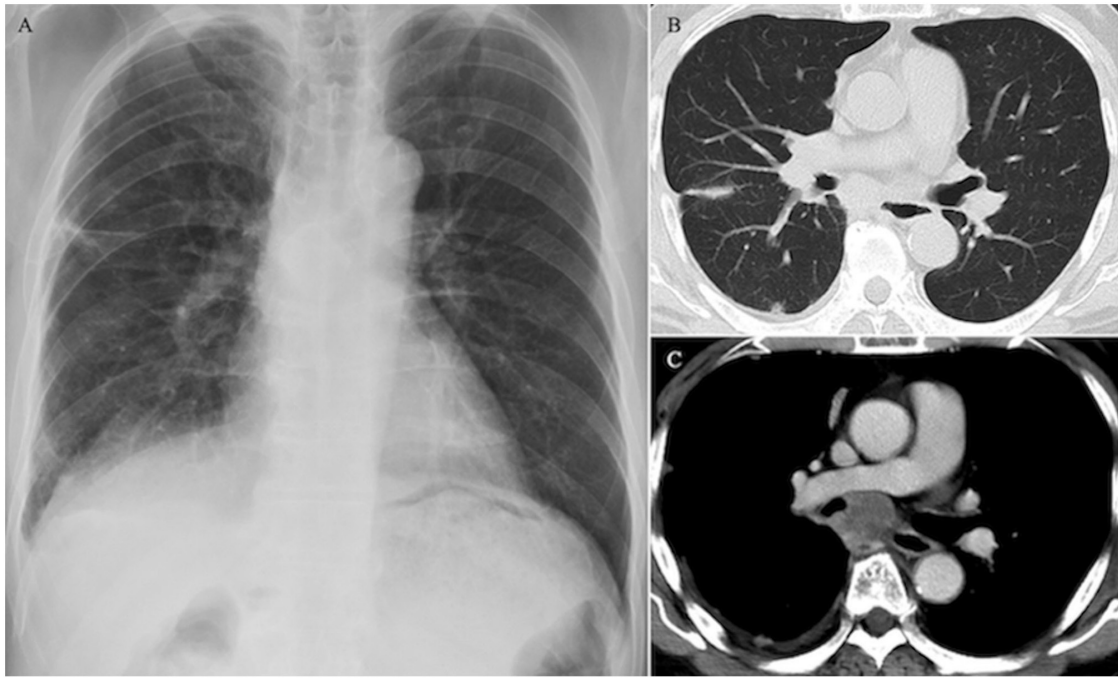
Radiography and CT findings. (A) Chest radiography revealed linear opacity in the right middle lung field. (B) Trunk CT revealed multiple thickenings in the right pleura and right pleural effusion. (C) Trunk contrast-enhanced CT revealed a hilar mass shadow with contrast enhancement along the right main bronchus from below the tracheal bifurcation. There were no findings to explain the nausea, despite the slight thickening and contrast enhancement on the stomach wall. CT, computed tomography.
